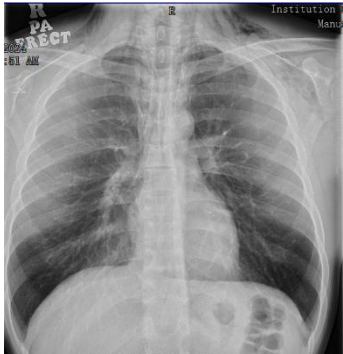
Chest X-ray upon presentation
